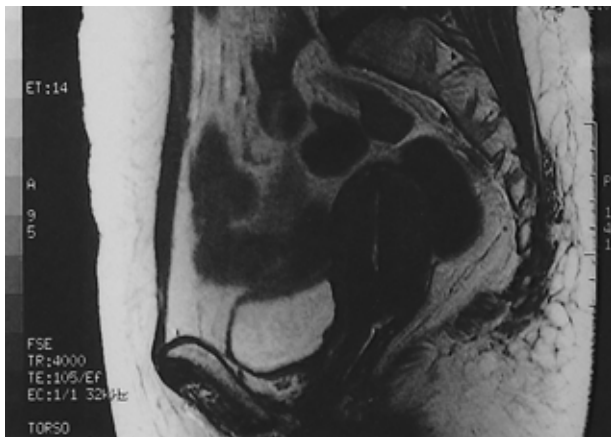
Follow-up abdomen and pelvic MRI scan shows no cervical mass.
